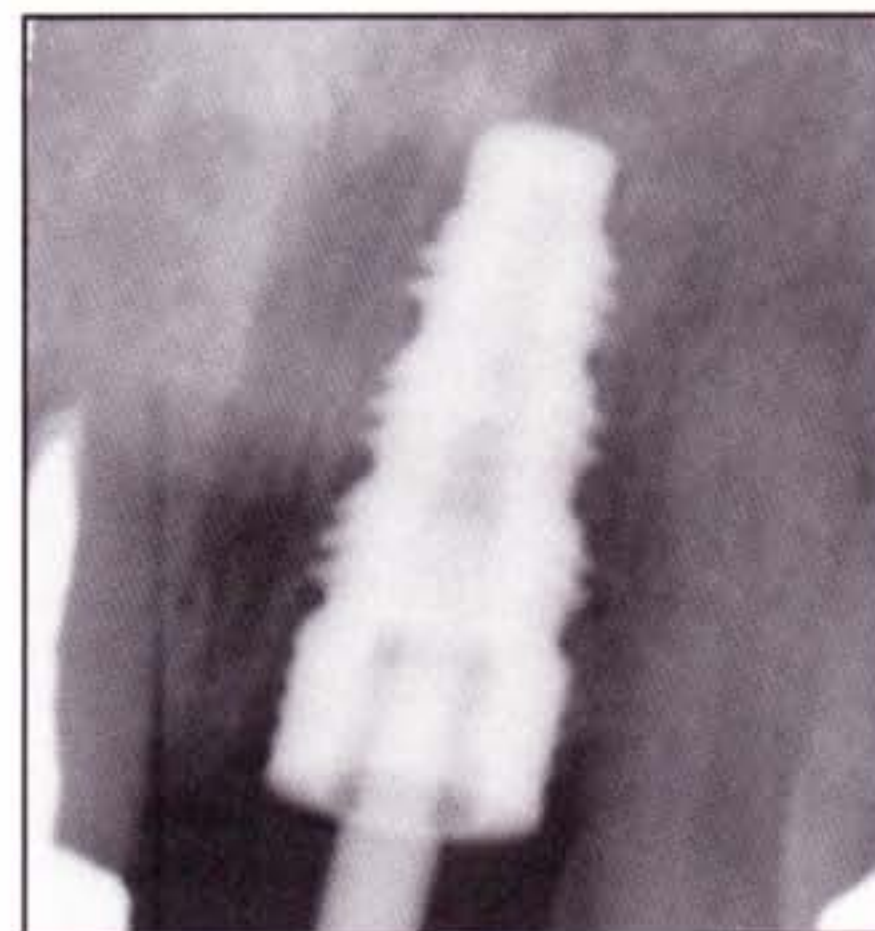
Periapical radiograph showing perfect adaptation of the implant to the ad hoc prepared extraction socket.
